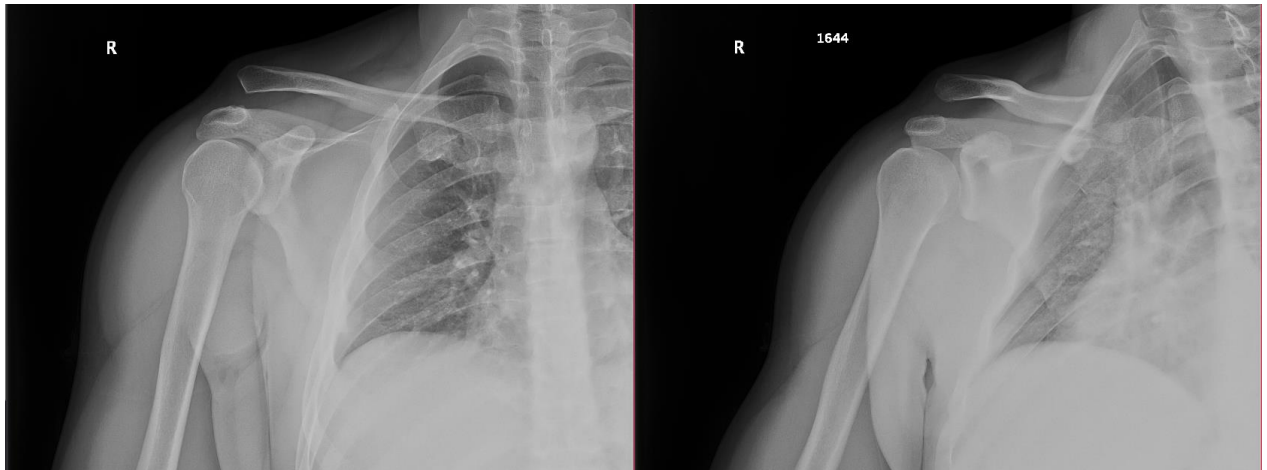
06.07.2021 X-Ray Right Shoulder
